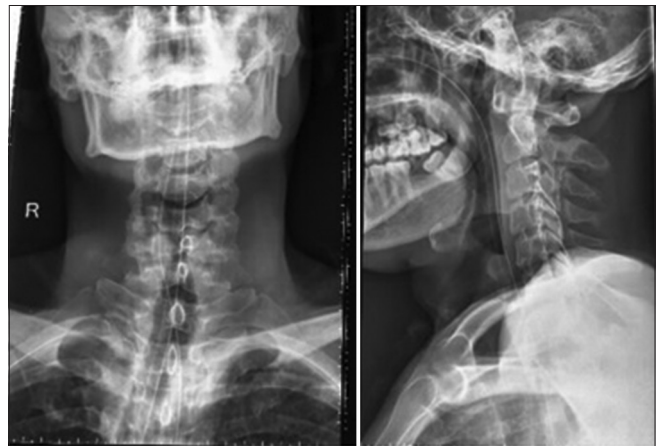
X-ray cervical spine (AP/LATERAL): Normal Study
